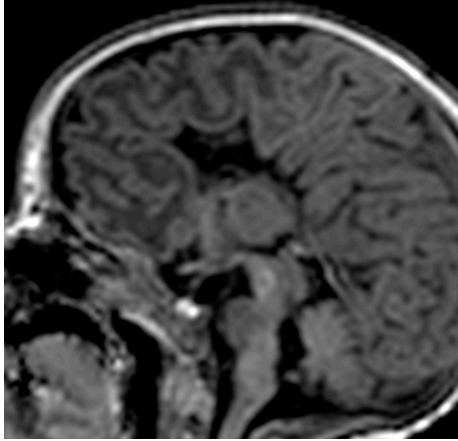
Midline T1 sagittal MRI scan demonstrates an easily identifiable isthmus (arrow) in an 11-year-old boy. Note the absent posterior pituitary bright spot
